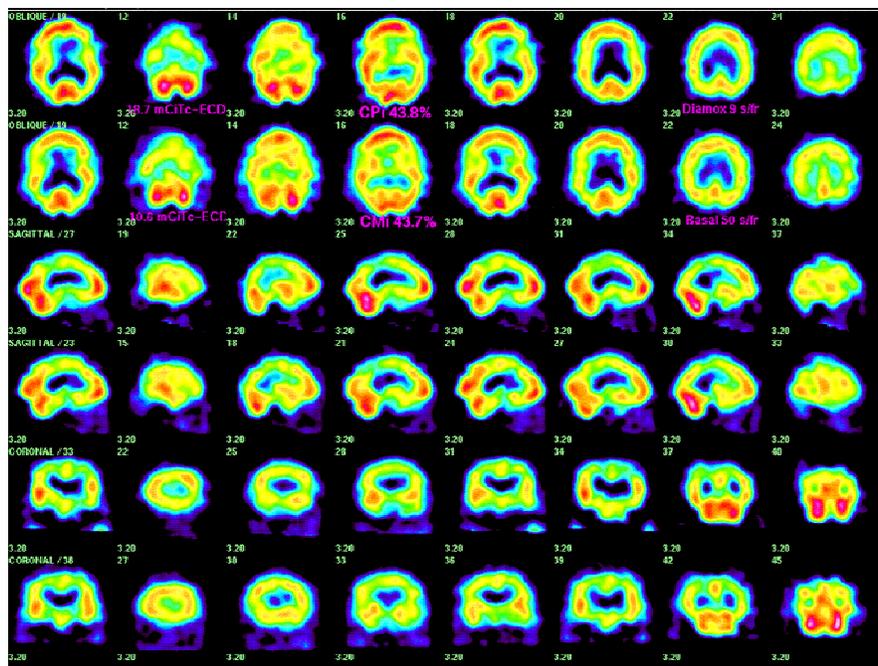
(above) Brain SPECT was performed rapidly for an 86 year-old hypertensive man (initial untreated BP at age 84 yrs was 174/94) with short-term memory loss had rapid protocol Brain SPECT shown to the right. Tc-99m-ECD behaves as a perfusion tracer during the initial approx 3 min and has stable Cerebral activity after 1 min allowing a rapid perfusion SPECT (Top of each of 3 paired rows of images). After 40 min the pattern from the same tracer is dominated by energy-dependent metabolic fixation of the tracer (Bottom of each of 3 paired image rows). The cerebral flow reserve (CFi) in this patient is 1.1%, near the lower limit of normal 1.06% and similar to the mean CFI (0.12+-7.69)% noted in 183 hypertensive patients with neurological complaints who did not have renal disease. Including 67 hypertensive patients with renal disease did not change CFI significantly (0.16+-8.02)%. The incidence of strokes in hypertensive patients without Rd was 22/184 or 12.0% and increased to
